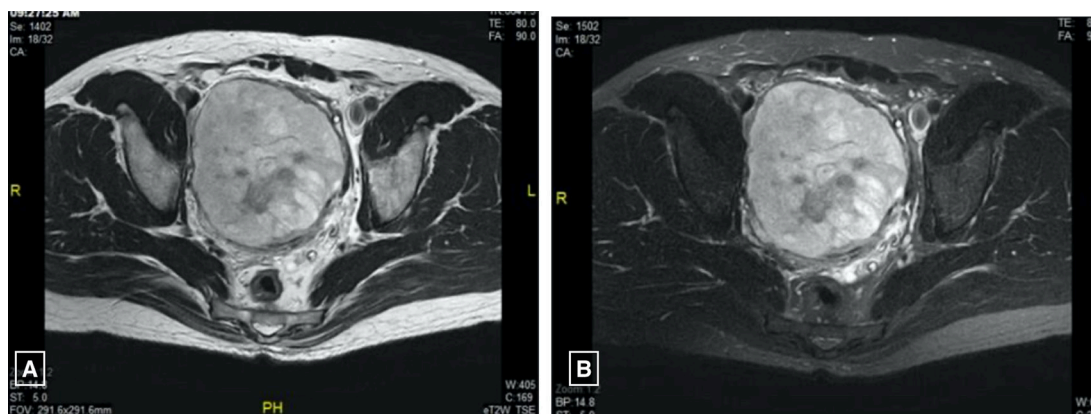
T1WI without contrast axial view (A) without fat suspension (B) fat suspension sequence showing no lower signal intensity in the tumour as typically seen in other fatty tissue. T1WI, T1-weighted imaging.
